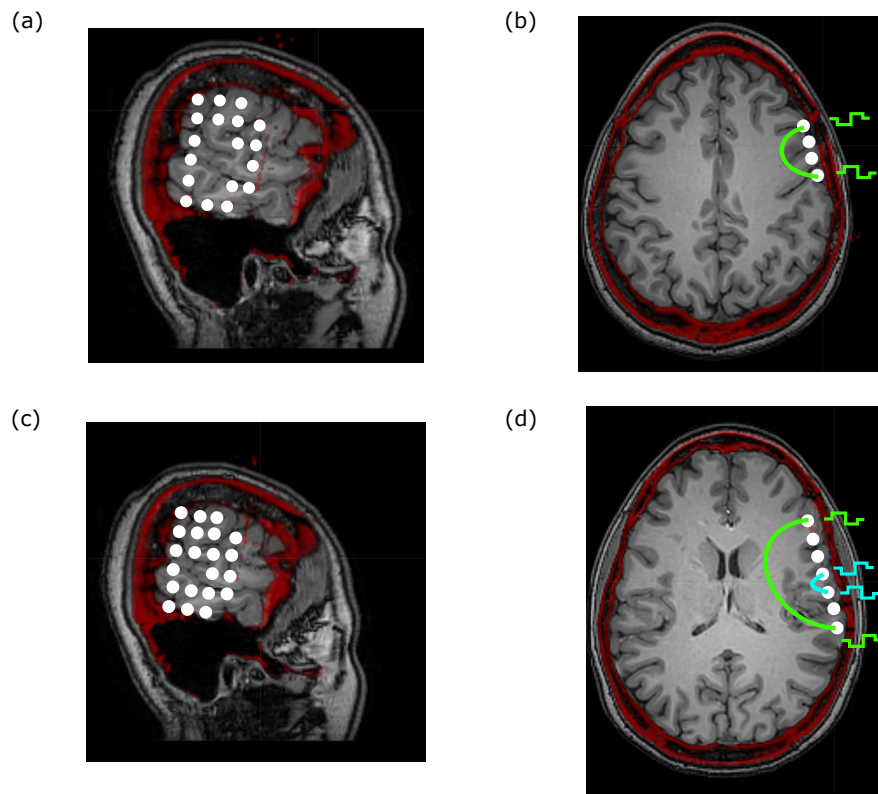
Example co-registered patient CT and MRI with current flow paths. Here we show one of our patients with their postoperative CT and preoperative MRI co-registered, and highlight the complicated geometry that current must flow through between the two electrodes. Panels (a) and (c) highlight a sagittal view through the brain. White dots represent electrode locations as visualized in the CT. Panels (b) and (d) are the corresponding axial planes for panels (a) and (c). Of note is that the overall shape brain on the larger scale could be considered spherical or ellipsoidal, while on a local scale there are the complicated folds of the gyri and sulci. In panels (b) and (d) we highlight two potential current paths through the cortex, depending on the separation of the stimulating electrodes. With greater separations, the depth of penetration increases, and there are varying layers of gray, CSF, and white matter depending on the path. In panel (d), it appears as if this set of electrodes lies on a flat line. Therefore, one could question what the best geometric model would be for these electrodes. A flat half-space fits the electrode positions well, but ignores the global geometry of the brain. However, the electrodes would not lie perfectly on any sphere. Therefore, we consider both spherical and flat models to test how assumptions about geometry affect our results.
